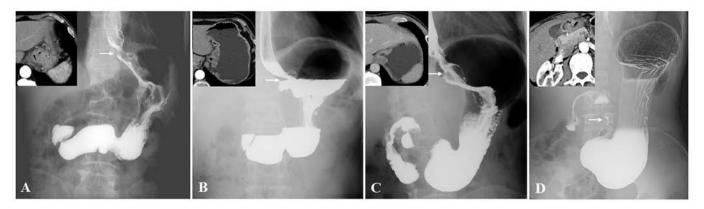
Different types of gastric morphological type for T3 stage and T4 stage GC. (A) Case of a 76-year-old male with GC located at the upper segment (arrow) based on upper gastrointestinal barium X-ray image. The inset image is the CT image. Upper gastrointestinal barium X-ray examination diagnosed a hook-type stomach. The postoperative pathology data proved to be of a moderately differentiated adenocarcinoma, intestinal-type GC and T4 stage disease. (B) Case of a 39-year-old female with GC located at the upper segment (arrow) based on upper gastrointestinal barium X-ray image. The inset image is the CT image. Upper gastrointestinal barium to be of a poorly differentiated adenocarcinoma, diffuse-type GC and T3 stage disease. (C) Case of a 55-year-old male with GC located at the upper segment (arrow) based on upper gastrointestinal barium X-ray image. The inset image is the CT image. Upper gastrointestinal barium X-ray examination diagnosed a horn-type stomach. The postoperative pathology data proved to be of a moderately differentiated adenocarcinoma, intestinal-type GC and T4 stage disease. (D) Case of a 55-year-old male with GC located at the lower segment (arrow) based on upper gastrointestinal barium X-ray image. The inset image is the CT image. Upper gastrointestinal barium X-ray examination diagnosed a weak-type stomach. The postoperative pathology data proved to be of a poorly differentiated adenocarcinoma, mixed-type GC and T4 stage disease. GC, gastric cancer.
